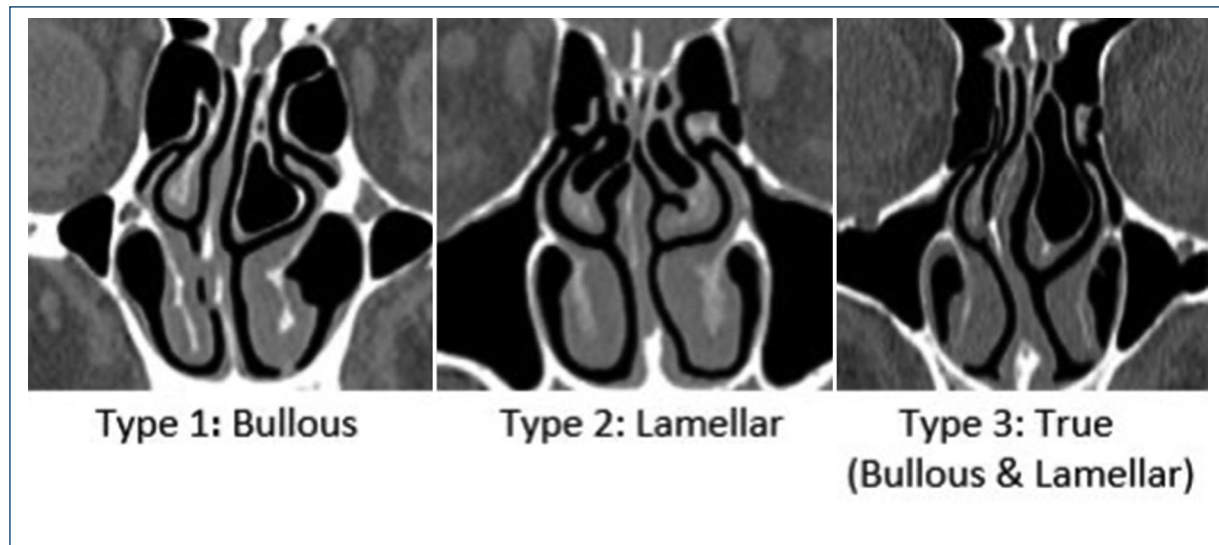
Coronal plane CT images showing the types of CB according to the classification by extent of pneumatisation in its different elements (Bolger).
